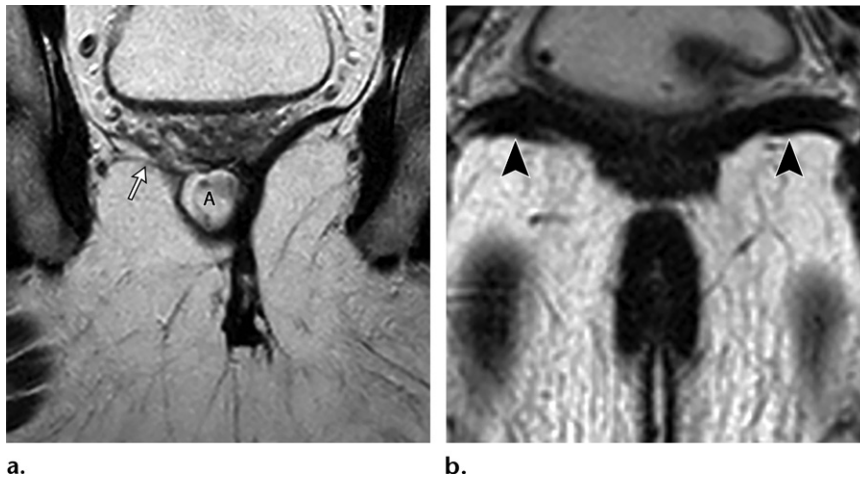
Different appearances of the iliococcygeus muscles in two men. (a) Coronal T2-weighted non-fat-saturated MR image in a 56-year-old man who was previously treated with abdominoperineal resection and who had a normal left iliococcygeus muscle shows atrophy of the right iliococcygeus muscle (arrow), which most likely is secondary to invasion from recurrent rectal adenocarcinoma (A). (b) Coronal T2-weighted non-fat-saturated MR image in a 22-year-old man with pelvic floor pain and difficulty in defecation shows bilateral thickening of the iliococcygeus muscles (arrowheads).
